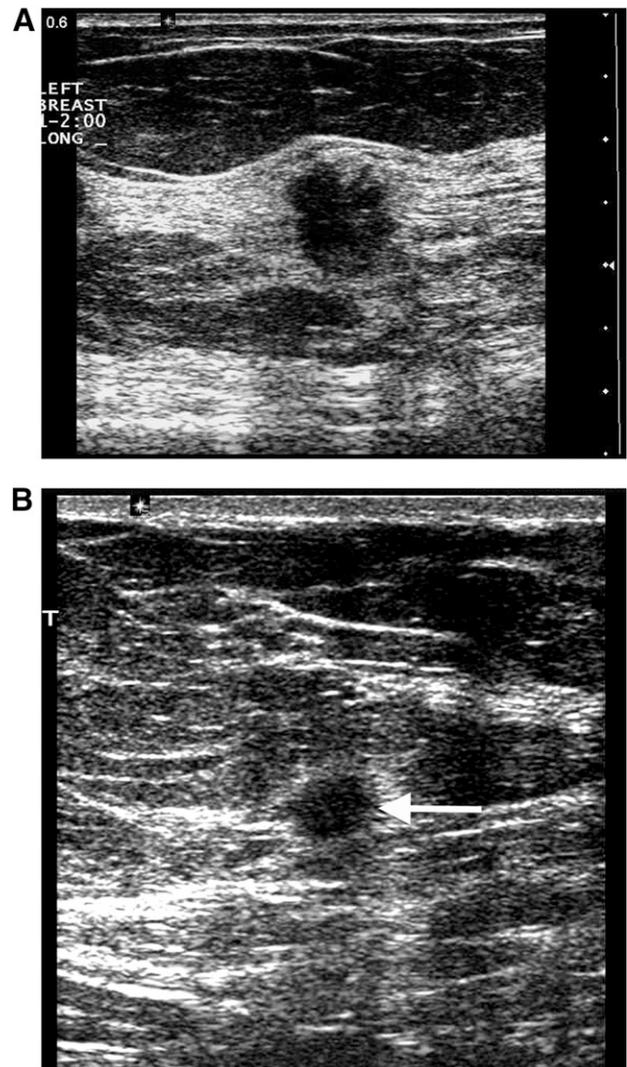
Measurement of a primary breast tumor (T category). (A): Sonogram shows a small (1-cm) T1 tumor. The tumor is markedly hypoechoic, and its margins are well demarcated from the adjacent echogenic tissues. This makes measurement of the tumor easy and reliable. (B): Measurement of a minute (0.5-cm) round cancer (arrow) is easy because of the contrast between the hypoechoic tumor and the surrounding tissues.
